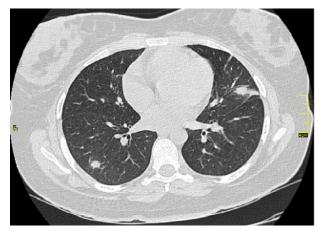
Computed tomography of chest showing lung nodules.
